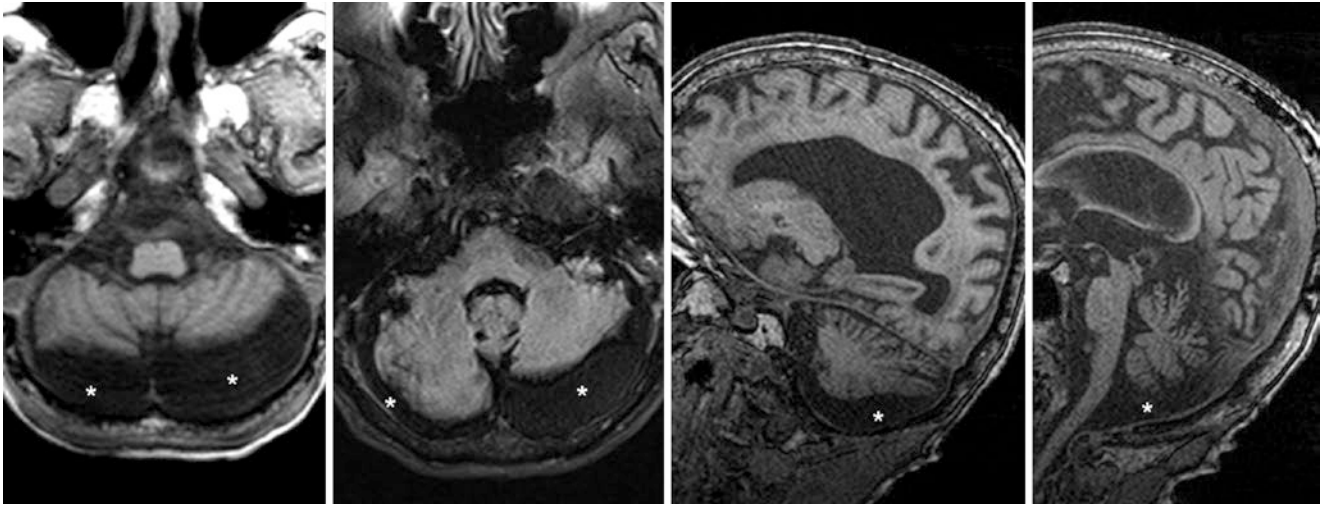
A 3T MRI of a 54 year old showed bilateral fluid collections (*) along the cerebellar convexities on axial T1WI (*left*) and FLAIR (*left middle*), which mimic chronic SDHs. Notice the lack of mass effect and that the signal intensity is the same as that of CSF. These
